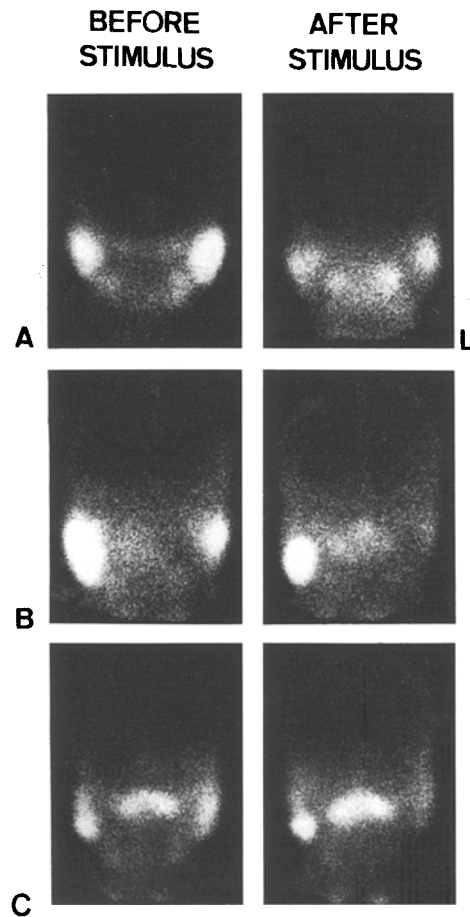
^{99m}Tc -pertechnetate salivary scintigrams before and after ascorbic acid stimulation. A Unilateral parotitis on the left side: diffuse high uptake in the left parotid gland before stimulation and symmetrical washout on both sides. B Warthin's tumor: diffuse high uptake in the right parotid gland before stimulation; focal high uptake in the tumor in the lower portion of the gland after stimulation. C Warthin's tumor: focal high uptake which became more apparent after stimulation
